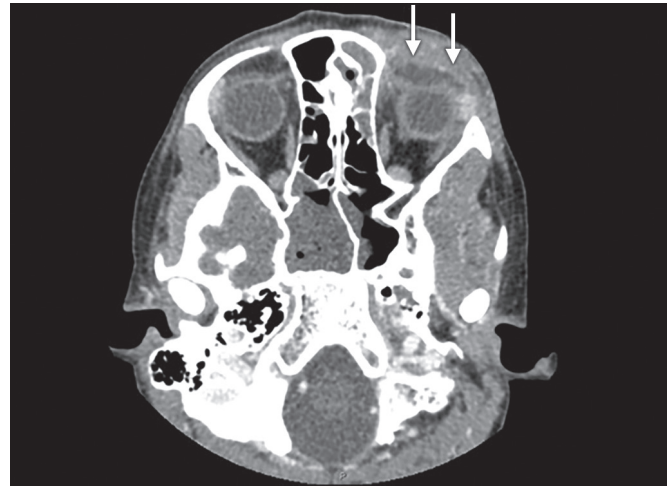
Axial CT scan after cessation of steroids demonstrating persistent subperiosteal abscess (arrows) in the superior aspect of the orbit.
